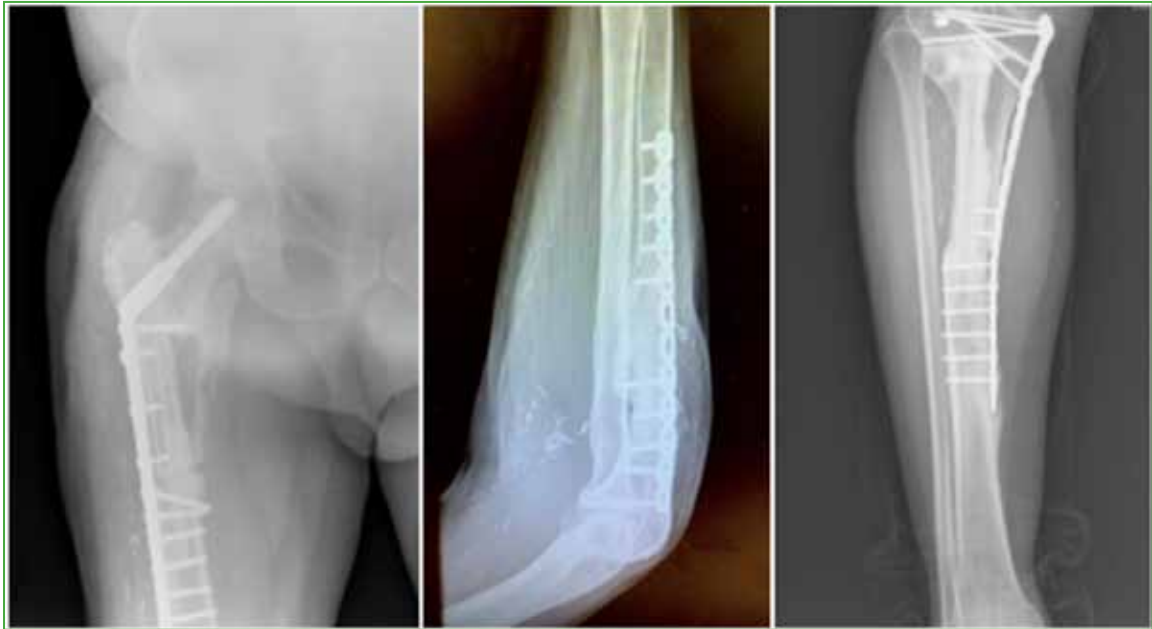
Anteroposterior radiographs of femur and tibia, and lateral radiographs of ulna after complete bone consolidation in radiographic controls.
